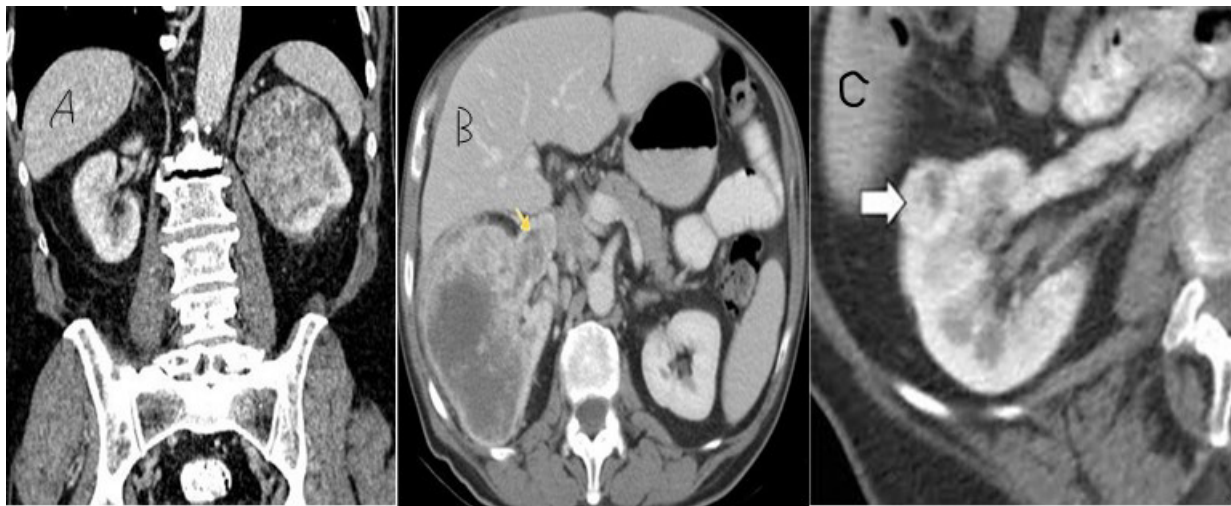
(A) Enhanced coronal CT scan shows a large soft tissue heterogeneous enhanced mass with cystic changes. (B) right kidney large RCC mass with vascular extension Arrowed. (C) well-defined small enhanced cortical kidney mass within the capsule.
